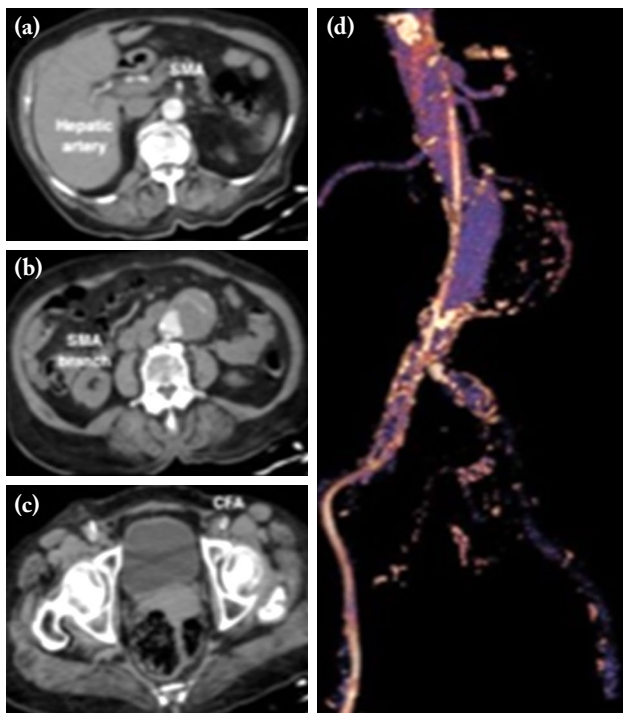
An example for IQS 2. TA-CTA images performed on an 86-year-old woman with an abdominal aortic aneurysm and chronic kidney disease before EVAR. On axial images, distal branches of visceral arteries and femoral arteries can be seen, as well as aorta. (a) Superior mesenteric artery and hepatic artery can be seen. (b) Superior mesenteric artery branch can be seen. (c) Common femoral arteries can be seen. (d) Not an enough quality for volume rendered image.
